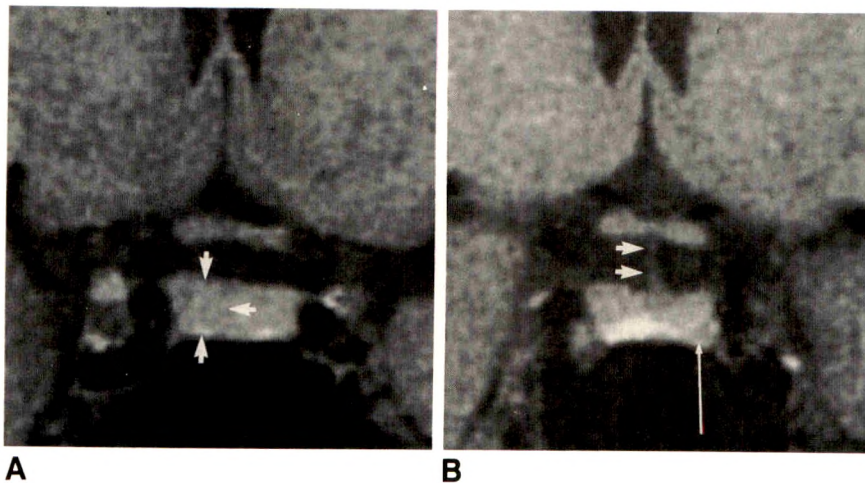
27-year-old woman with Cushing disease. T1-weighted coronal images, 600/20.
